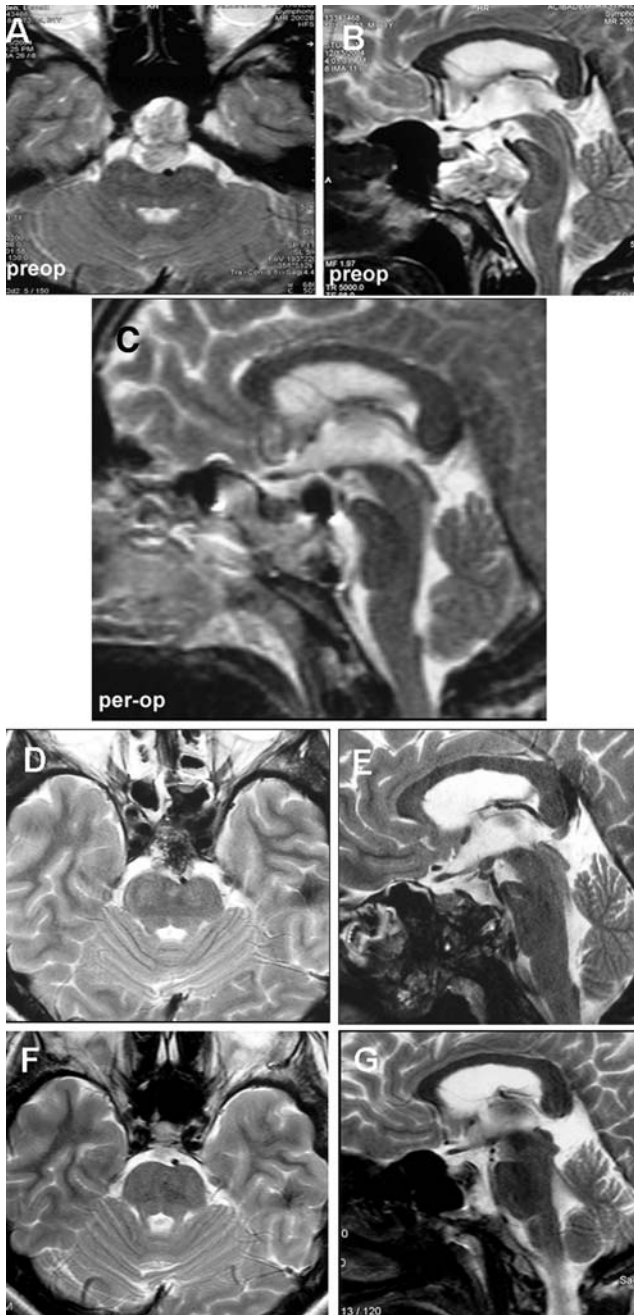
Use of intraoperative MRI. for a clivus chordoma. T2w MRI of a patient showing preoperative (A and B), intraoperative (C), early postoperative (D and E) and postoperative 15th month (F and G) images
